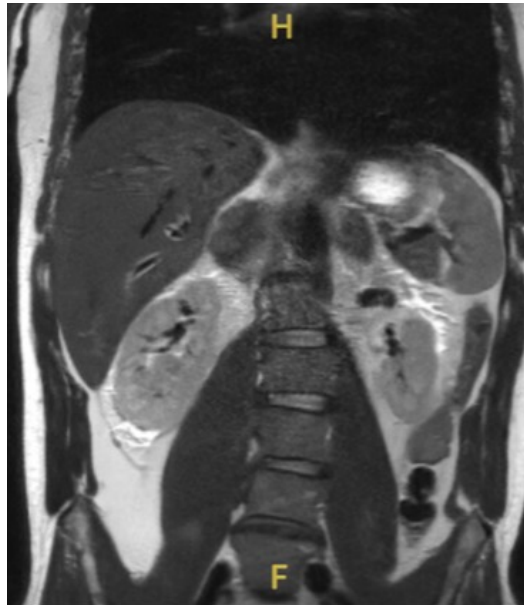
MRI Abdomen and Pelvis. This abdominal MRI demonstrates bilateral adrenal abnormalities with minimal enhancement and signal changes consistent with hemorrhage as opposed to solid lesions. Furthermore, there are mildly enlarged retroperitoneal lymph nodes observed, which are more numerous than we would typically expect. Additionally, the liver shows signs of steatotic liver disease. The findings described in the imaging are consistent with acute bilateral adrenal hemorrhage in the appropriate clinical context. Follow-up imaging is necessary to assess for stability or resolution.
